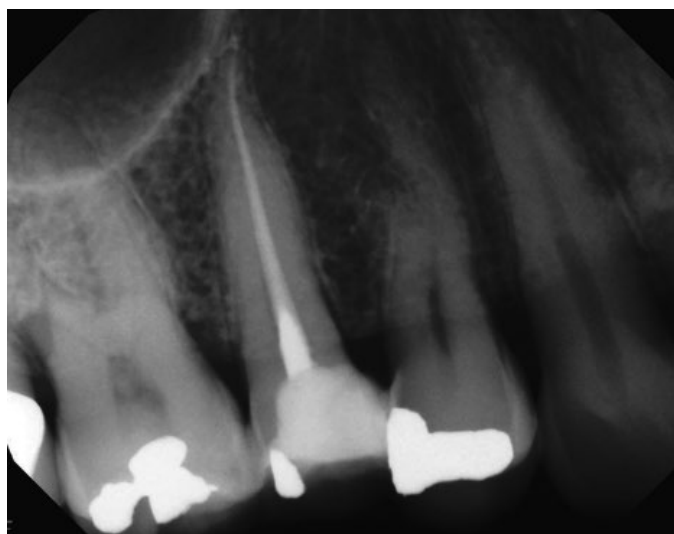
(B) Radiograph taken 15° from the mesial. Only one canal visible. Reproduced with permission of Dr J. Chikvashvili.
